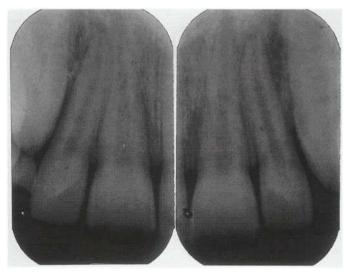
Root fractures: indistinct on periapical view.
